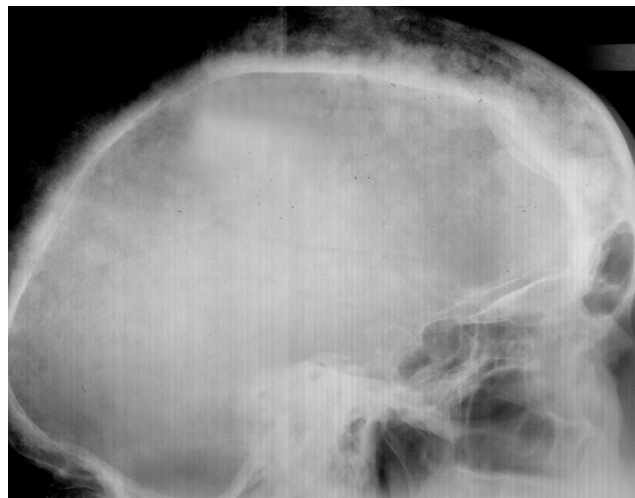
A lateral skull radiograph showing a radiopaque image with a cotton wool appearance typical of PD, mainly in the frontal and parietal bones.
